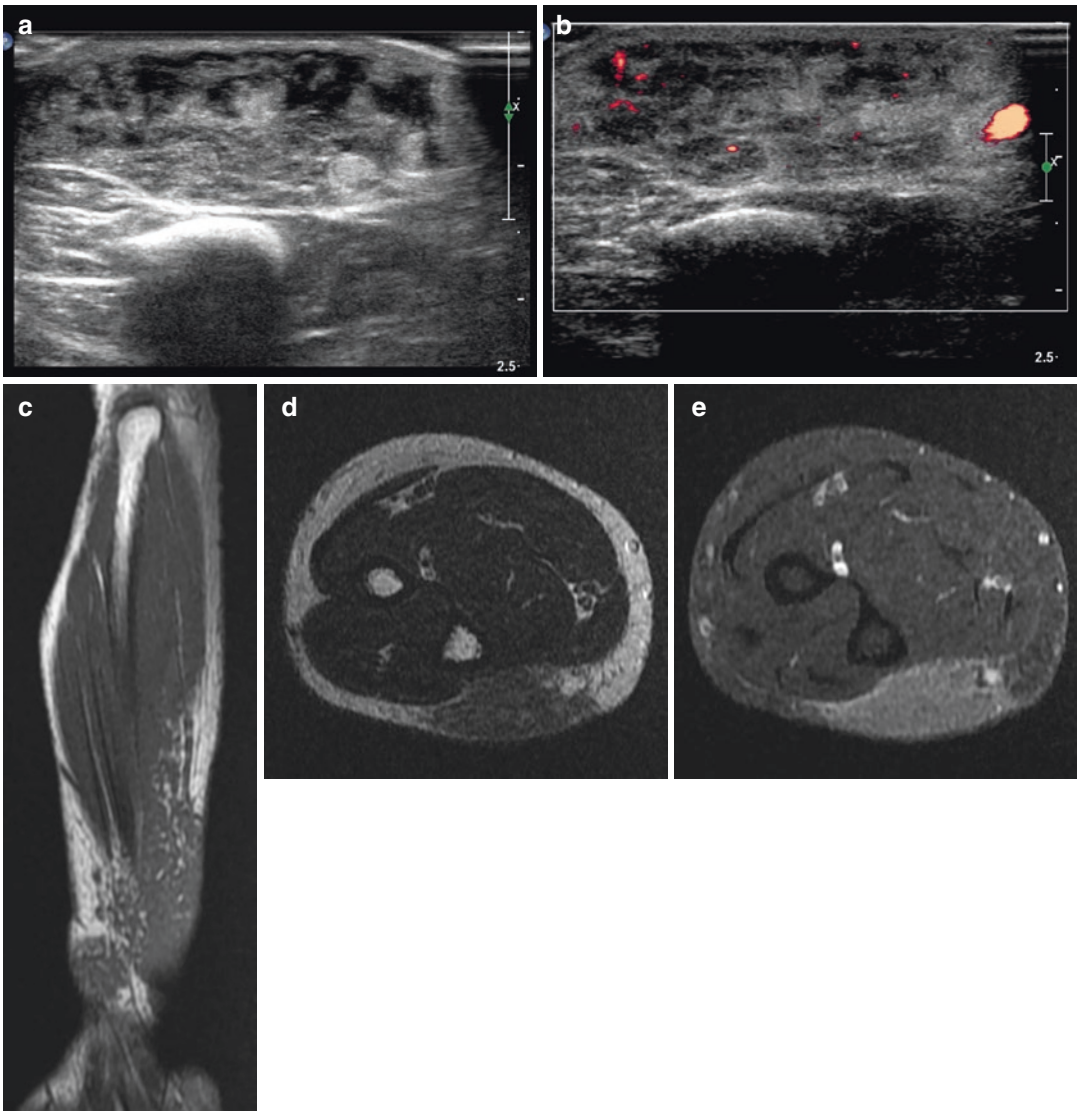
Subcutaneous sarcoidosis. Transverse US (a) of the forearm shows a heterogeneous echogenic mass in the thickened subcutaneous tissue. Color Doppler study (b) reveals several Doppler signals within the subcutaneous mass. Coronal T1WI (c) shows poorly defined subcutaneous
